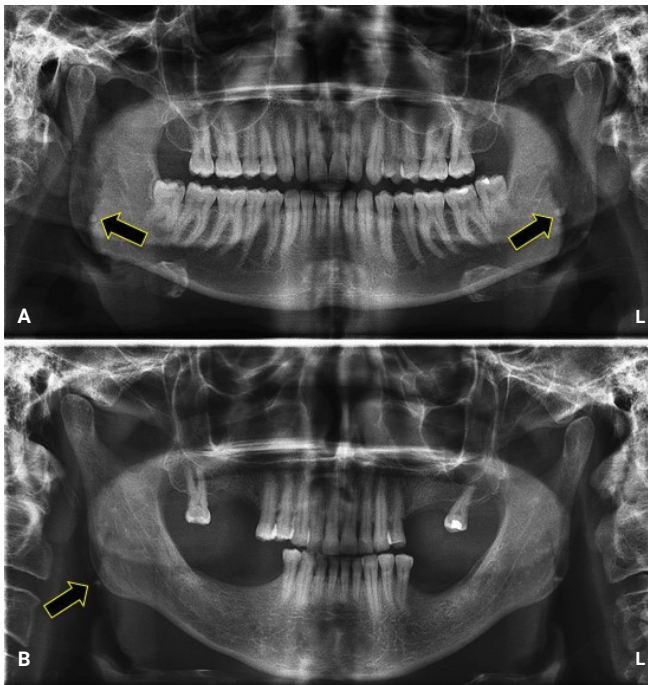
(A) The arrows on the panoramic radiograph showing well-defined circular radiopacities in the internal aspect of inferior alveolar canal bilaterally suggestive of phleboliths. (B) The arrow on the panoramic radiograph showing a radiopacity near the angle of mandible on right side suggestive of sialolith.
